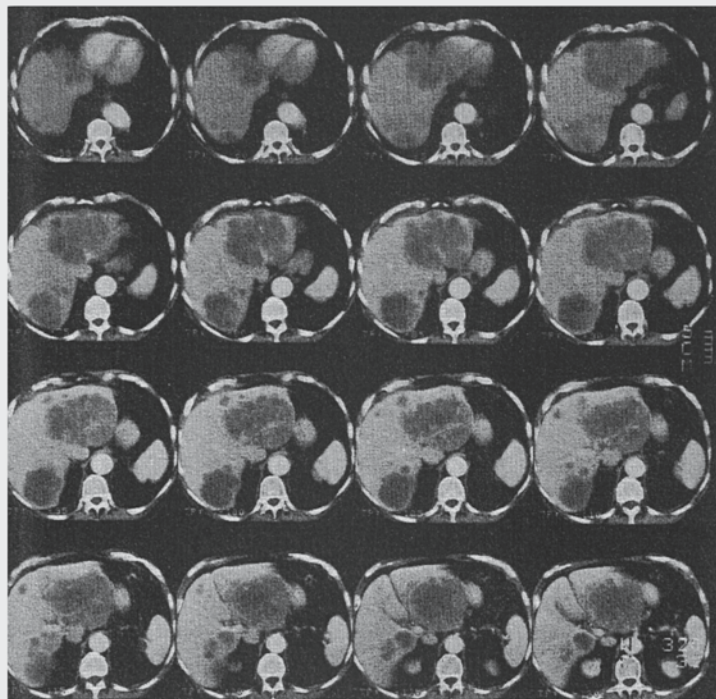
Spiral volumetric CT study, enhanced with contrast material, of multiple metastases in the liver from carcinoma of the colon (12 1-second scans of a 120-mm subvolume, 10-mm nominal section thickness, 10 mm/sec table feed). Sixteen consecutive reconstructions, spaced 5 mm apart, are shown.
